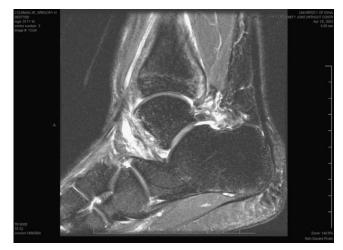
CT scan demonstrating avulsions of both the anterior and posterior ligaments but without diastasis.
